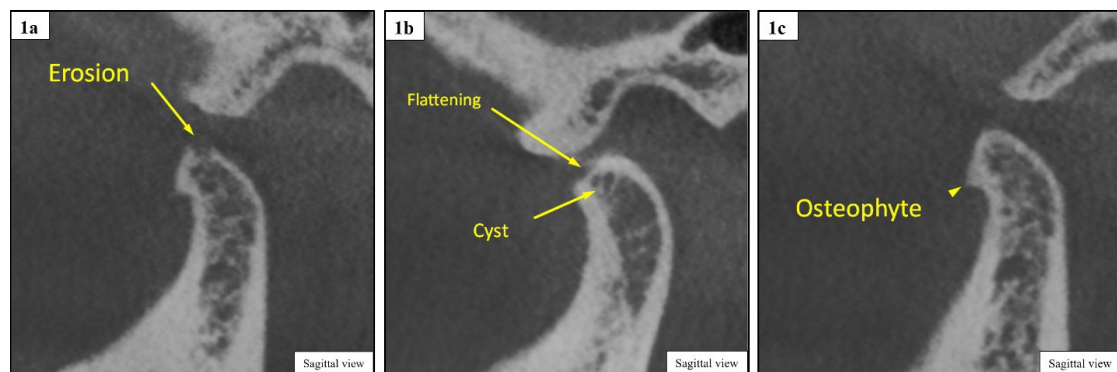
Sagittal section of CBCT image showing: a) erosion, b) osteophyte, c) flattening and subcortical cyst
